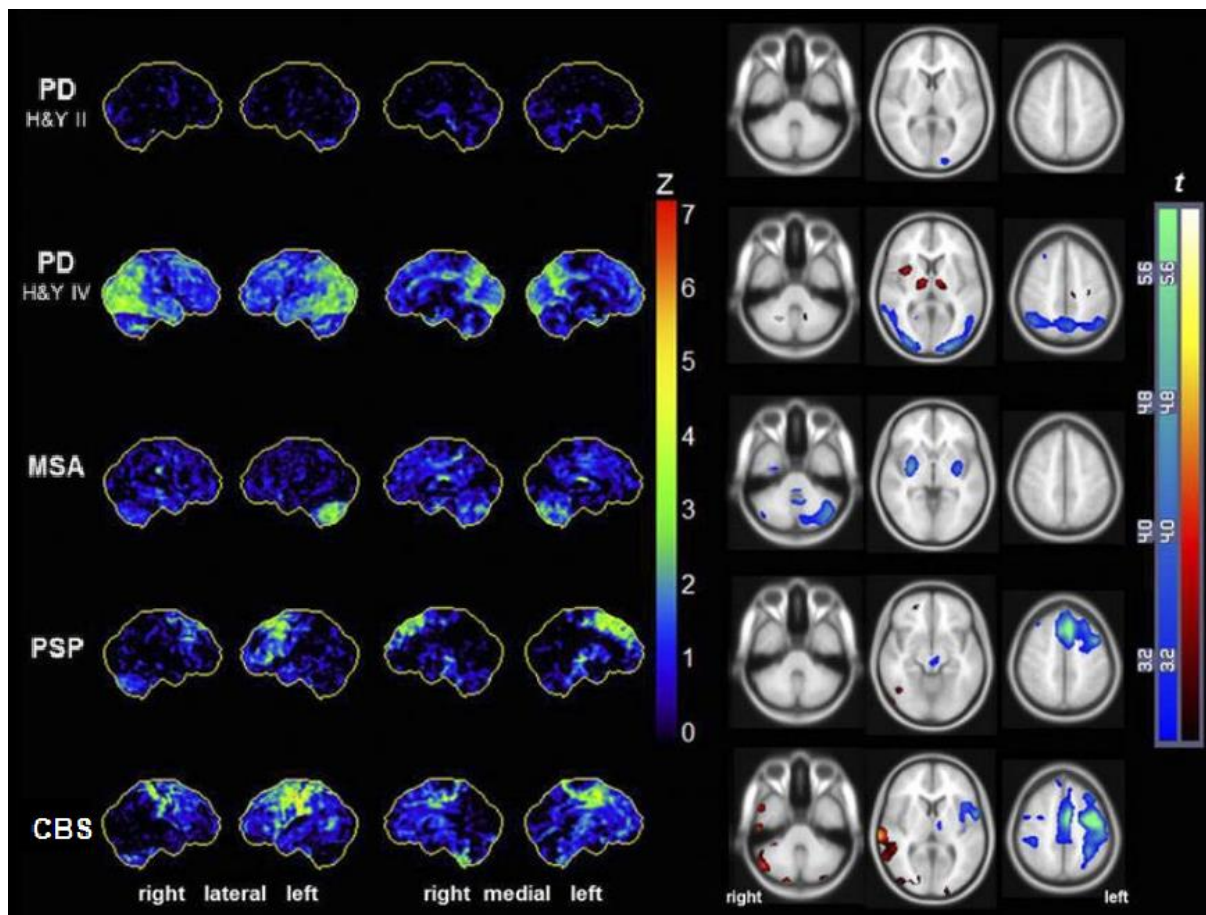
FDG-PET patterns associated to the different parkinsonisms. The first panel shows metabolic deficits compared with control subjects as z-scores. Second panel shows patient vs control results of a VBA as t maps. Adapted with permission of JNM from (Meyer et al., 2017).
